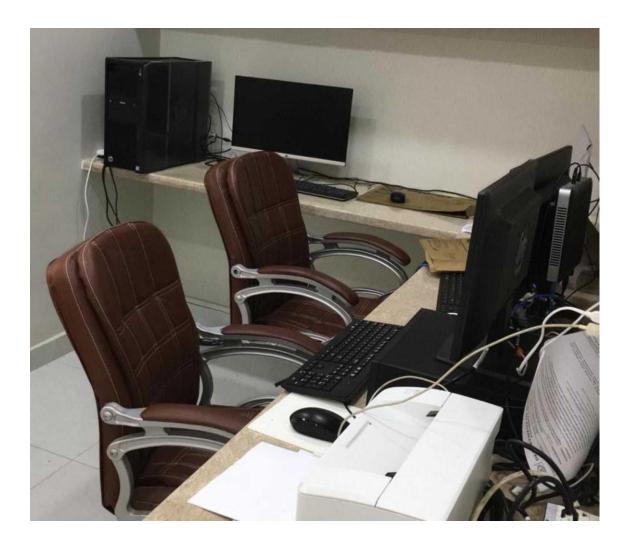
CT reporting room (From Research)
